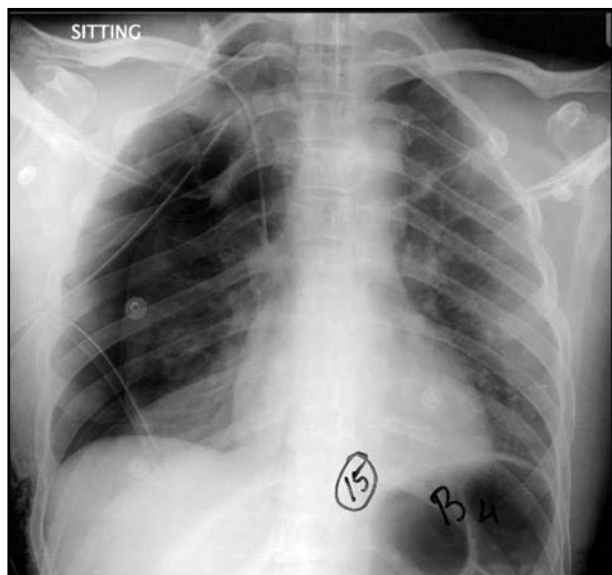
Postero-anterior chest radiograph showing two chest drains on the right side and pneumothorax
